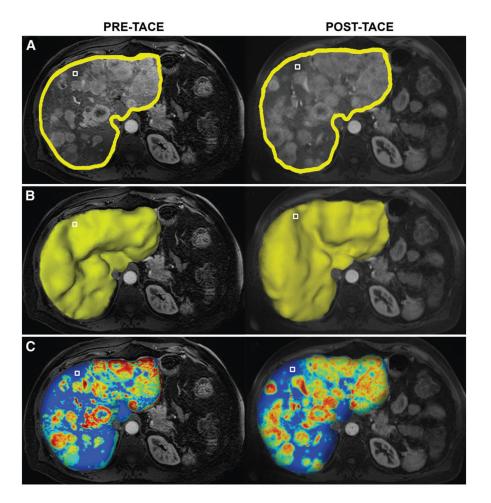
ETB. Pre-and post-TACE contrast-enhanced arterial phase T1-weighted MR images in 70-year-old man with NELM. A 3D ROI, depicted as white box in, *A*, liver segmentation outline and, *B*, 3D mask, was placed in normal liver tissue. *C*, On the basis of the definition of enhancement (>2 standard deviations the ROI's average signal intensity), the software automatically generated 3D color maps of liver, with red representing maximum enhancement and blue representing no enhancement.
